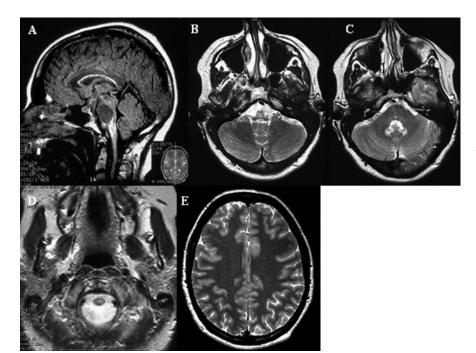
MRI demonstrating brainstem atrophy and high signal (sagittal fluid-attenuated inversion recovery [A]; axial T2 [B]), dentate high signal (C), marked spinal cord atrophy (D), and no cerebral pathology (E).
